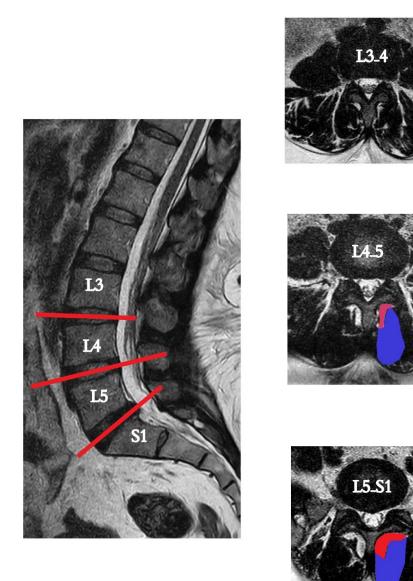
Lumbosacral MRI, of 27 years old lady with 6 years history of LBP without sciatica, BMI = 28, there is disc bulge at L5/S1 level. No neural canal stenosis. Average VAS score = 5. Axial cuts revealed grade 0 MF degeneration in at L3/4 level, grade 1 MF degeneration at L4/5 level and grade 2 MF degeneration at L5/S1 level, MF score = 3. Area of fatty infiltration in each of L4/5 and L5/S1 levels were colored in the left side by red, and the remaining muscle is colored in the left side by the blue
